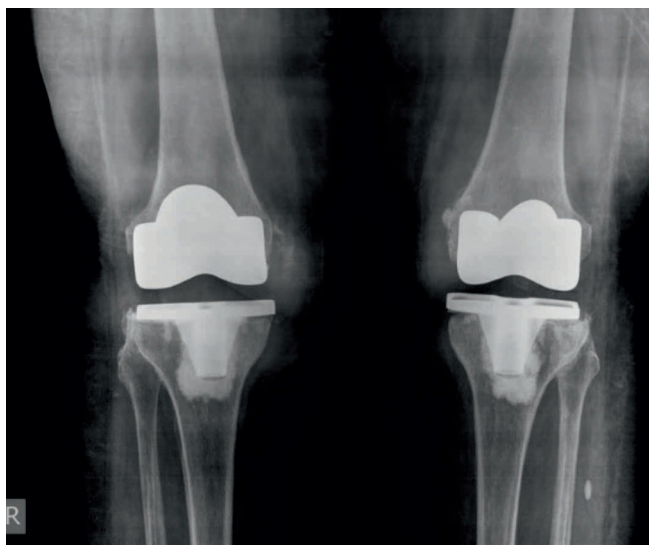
Bilateral peri-prosthetic joint infection following total knee arthroplasty due to *Salmonella typhi*—radiographs showing relatively well-fixed components with radiolucent lines under the tibial base plate.
